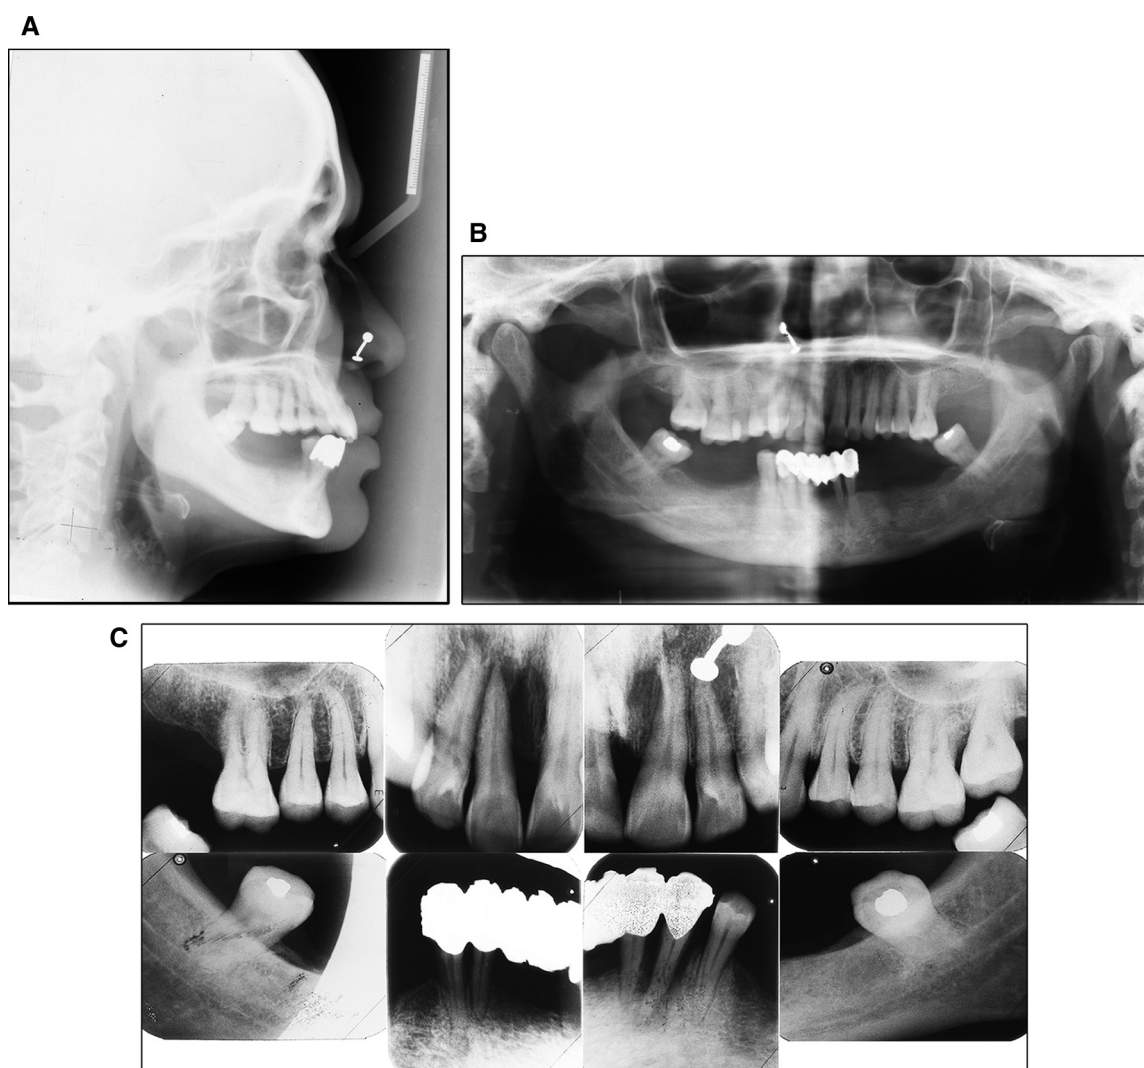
Pretreatment radiographs: A, lateral cephalogram; B, panoramic radiograph; C, full-mouth intraoral periapical radiographs.
